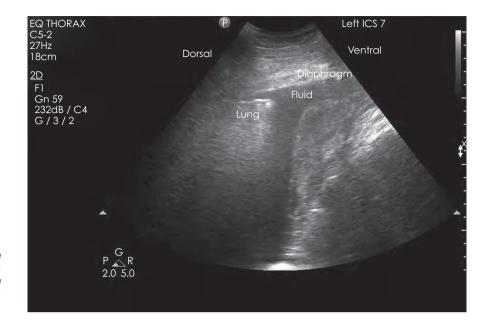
Thoracic ultrasonographic image at the left 7th intercostal space. Hyperechoic fluid indicating haemorrhagic fluid within the pleural space (image courtesy of Auburn University).
